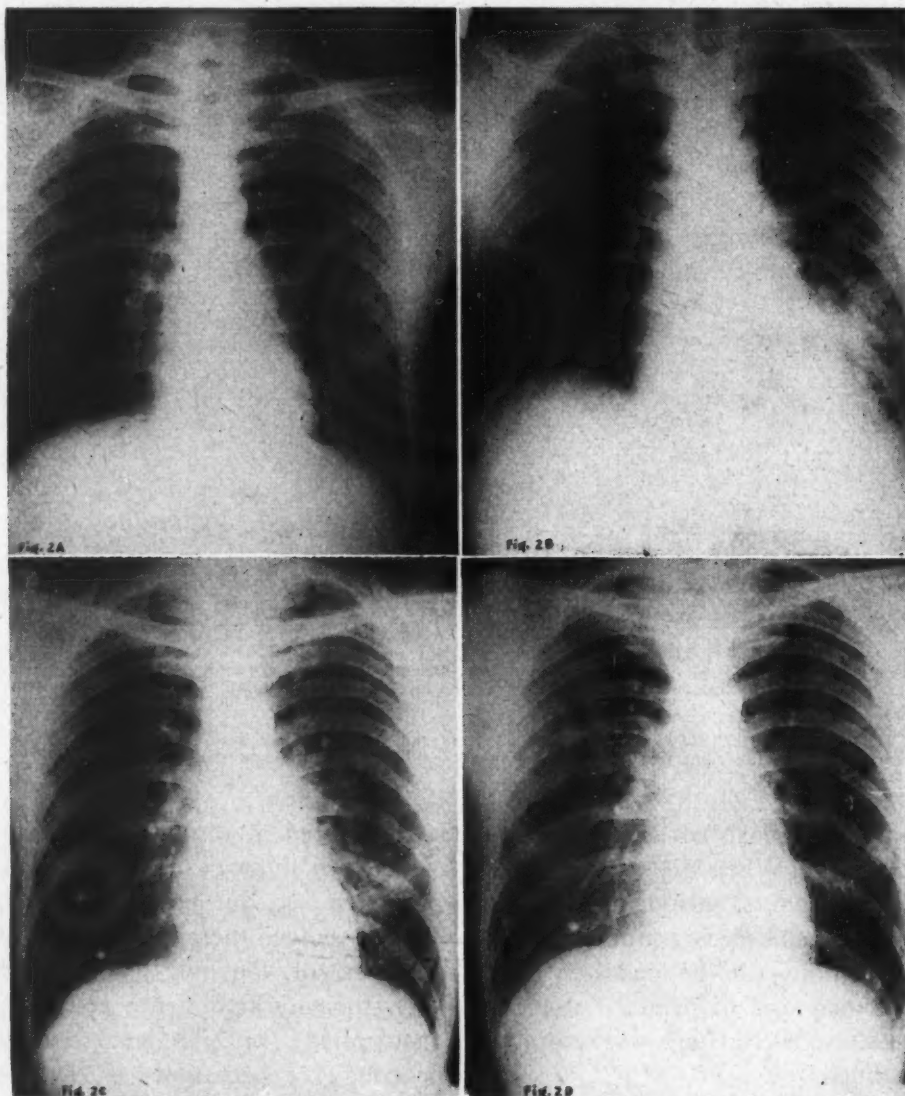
Case 2: R.C. Roentgenogram taken January 14, 1943, shows a definite diffuse patchy density extending down and out from the left hilus.
